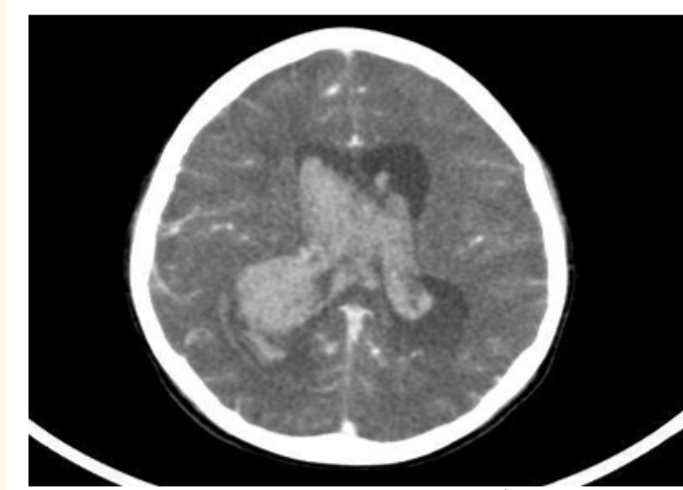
CT brain with contrast demonstrating Moyamoya syndrome.
